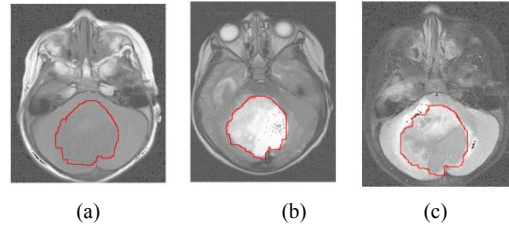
An example MRI slice for (a) T1 modality; (b) T2 modality; (c)FLAIR modality for patient #8. Tumors have been shown using boundary.
